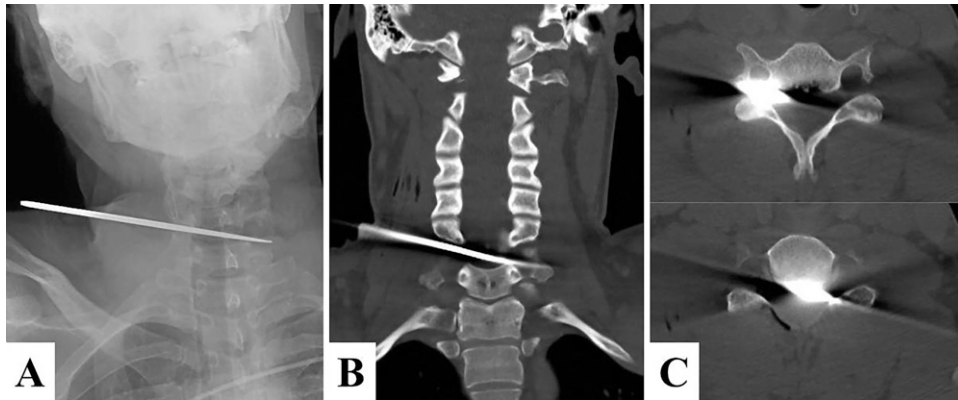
Anteroposterior radiograph (A) and CT of cervical spine (B and C) demonstrate a retained blade traversing the spinal canal at C6-C7. Note the retrovertebral blade trajectory anterior to the spinal cord and its proximity to the right vertebral artery in the foramen transversarium.
